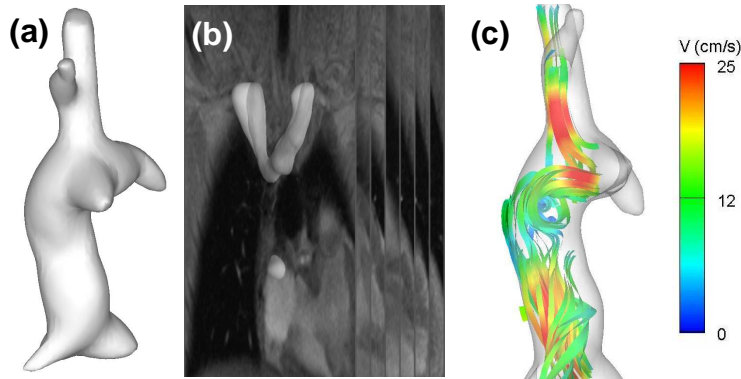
Various steps involved in the 3D velocity field reconstruction. a) TCPC geometry reconstructed from MRI, b) PC MRI planes registered onto the TCPC, c) Coronal view of the 3D stream lines reconstructed using divergence-free interpolation.
